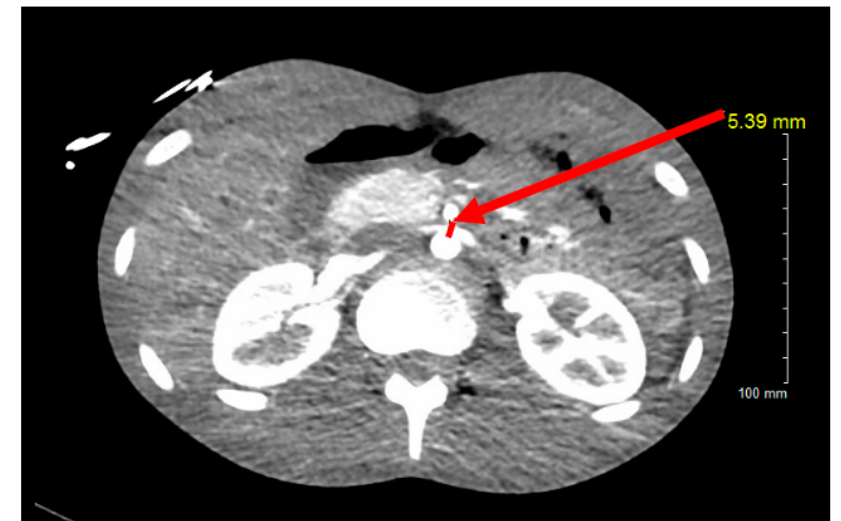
Computed tomographic angiogram (CTA) of the abdomen showing decreased aorto-mesenteric angle and distance suggestive of SMA syndrome. The aorto-mesenteric angle of 12 degrees and the aorto-mesenteric distance of ~5mm (demonstrated by arrow).
